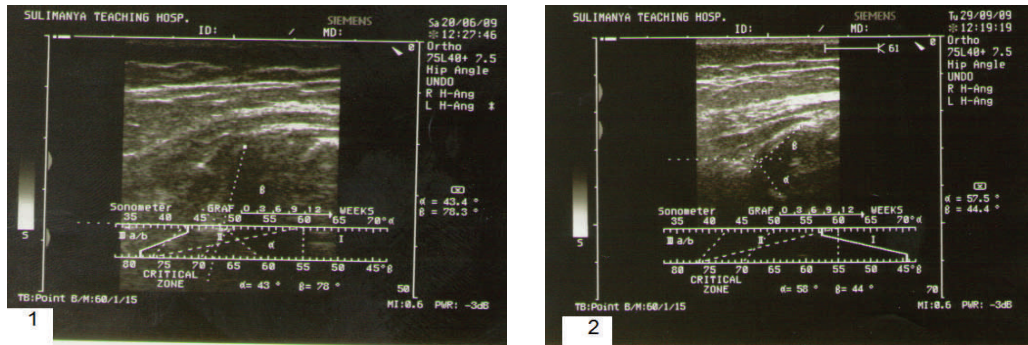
Ultrasound of the left hip joint shows the decentred hip Graf D (1), but normalized to Graf I (2) after three month’s treatment with Pavlik harness.
